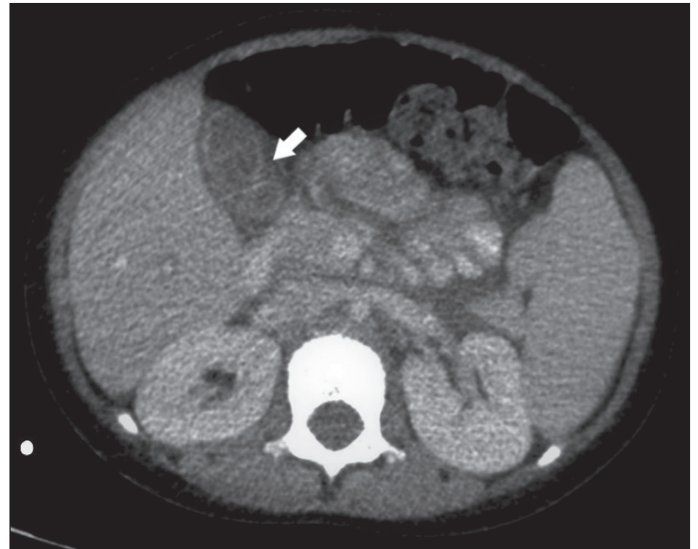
Contrast-enhanced abdominal CT in the axial plane.
